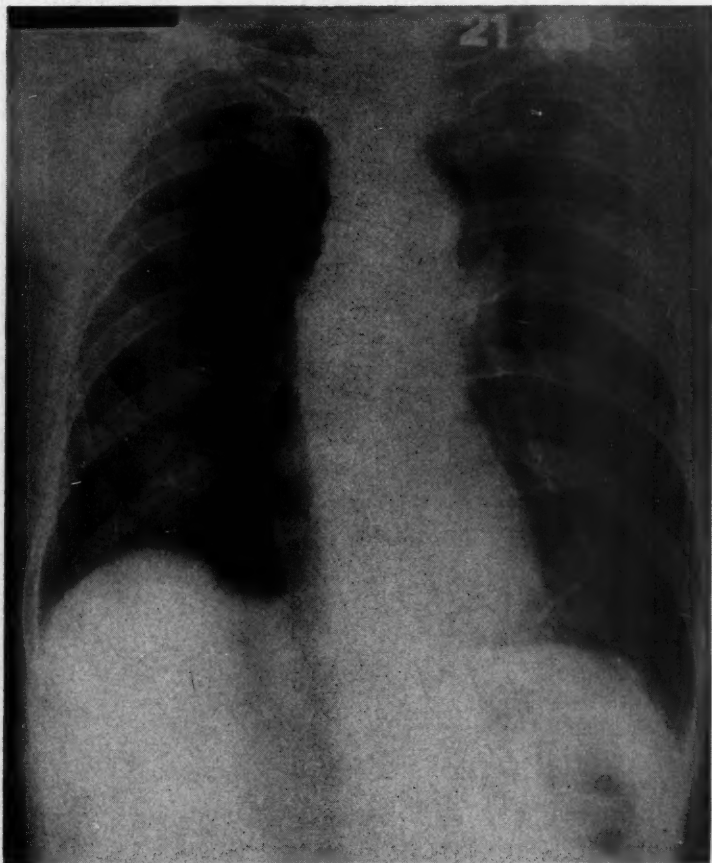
Roentgenographic appearance of the patient's chest on admission to the hospital.
